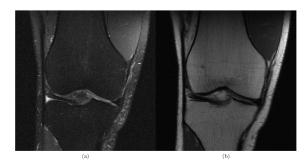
A PD knee image with fat suppression (a) and without (b). Being a soft tissue, fat as a high response in MRI, but makes details difficult to see [8].
